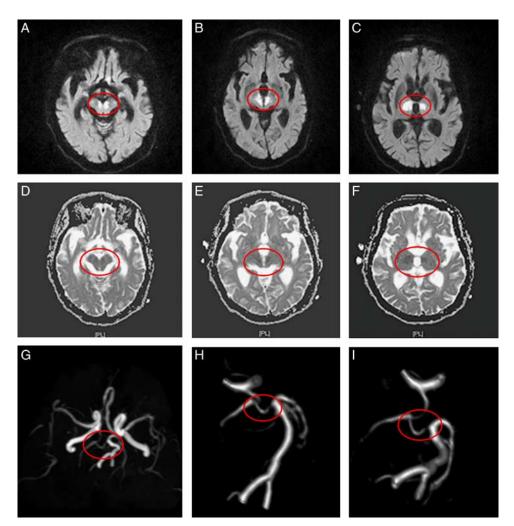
Cerebral images of the patient [magnetic resonance imaging (MRI and magnetic resonance angiography (MRA)]. (A–C) MRI, diffusion-weighted imaging sequence showing high-intensity foci in the paramedian thalamic areas (the red circles), the midbrain "V" mark could be observed in panel (B). (D–F) MRI, apparent diffusion coefficient imaging sequence showing low intensity foci in the same areas (the red circles). (G–I) MRA, different angles of the view of the right P1 segment of the posterior cerebral artery (the red circles).
